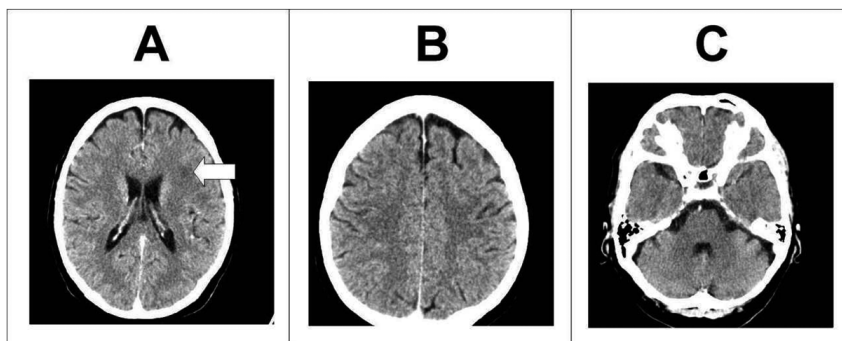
CT scan of WW's brain, July 2004. A – the white arrow shows a hypodense lesion in the white matter of the left temporal lobe; B – cortical atrophy, especially in the left frontal lobe; C – cortical atrophy in the right temporal lobe and anterior cortex of the cerebellum
